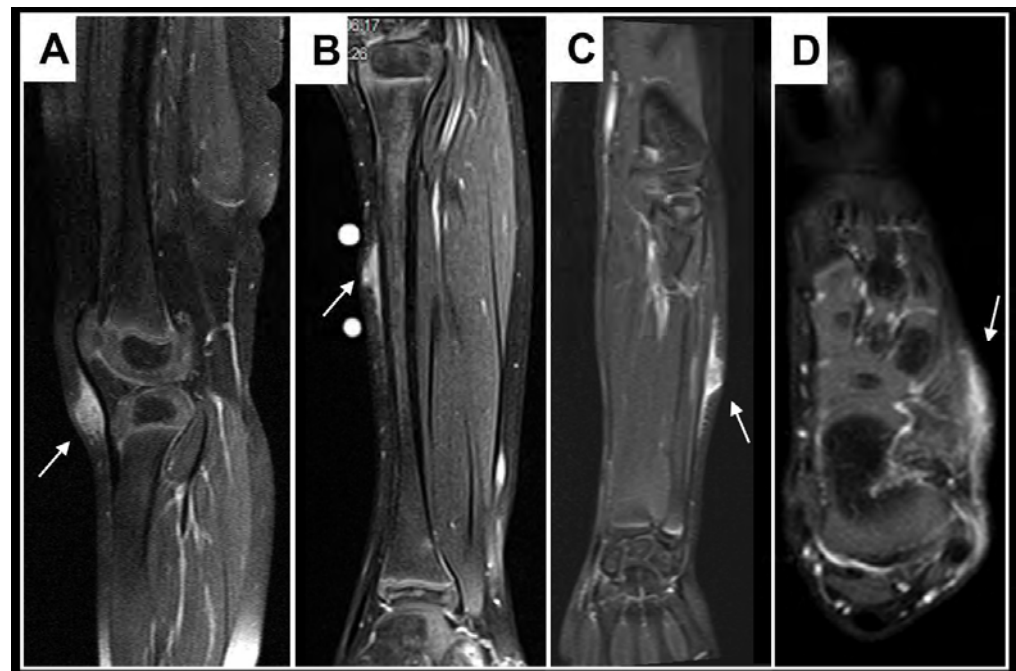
These images show representative MRI slices through SGA (indicated by white arrows) at the knee (A); lower leg (B); forearm (C); and foot (D) in four different cases. Note that all SGA lesions show the typical epifascial extension with gradual rise of the lesion towards the more superficial tissues, which we have named the “epifascial cap” sign.
